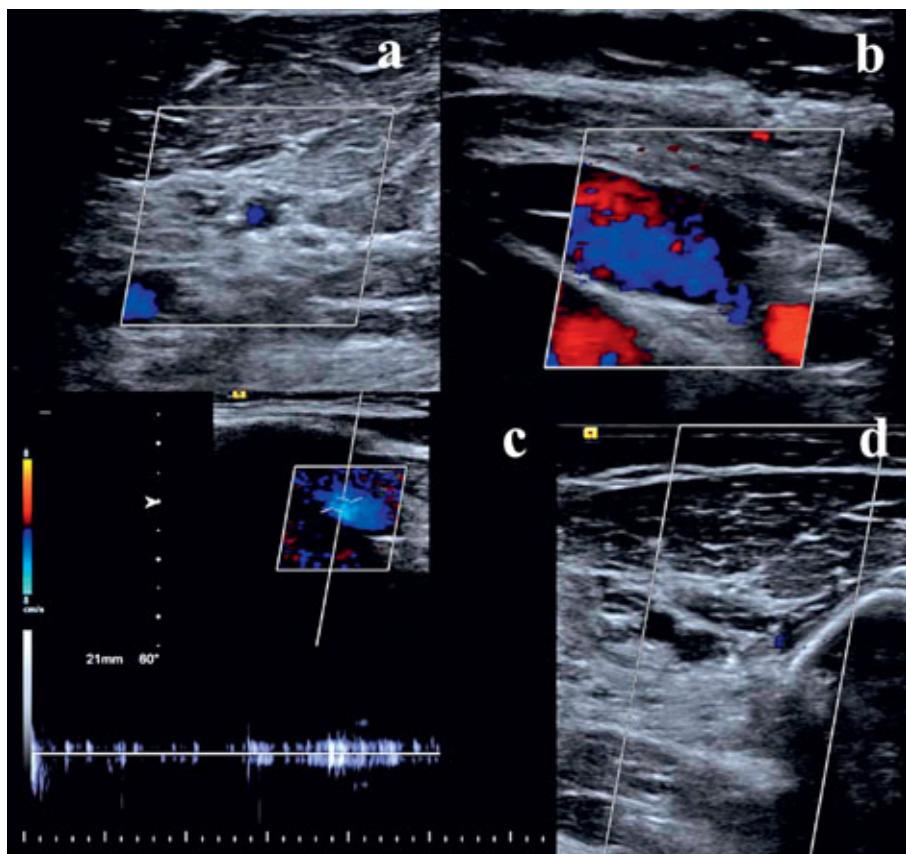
Duplex ultrasonography of deep veins of the left upper extremity, partial thrombosis of the brachial vein is imaged; upward images show the subclavian vein, downward the not fully compressible brachial vein is shown.
